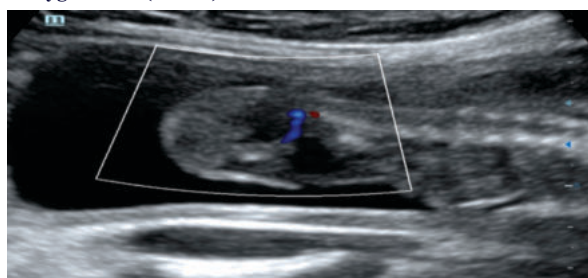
Sagittal section ultrasound image with doppler showing internal vascularity of the tumor
